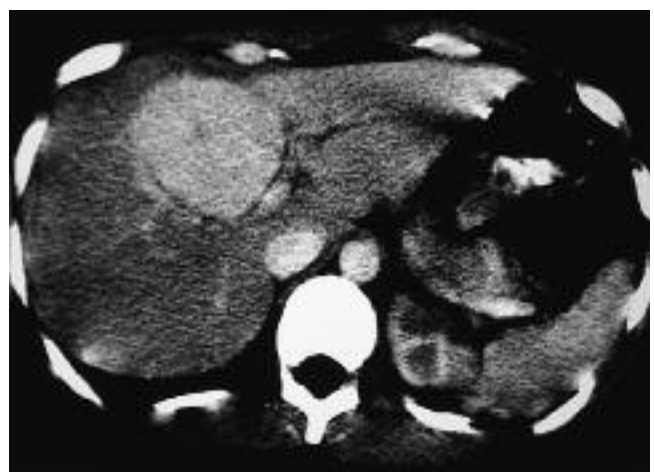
CT scan of a solid hepatic mass. The central 'scar' in this lesion suggests that it is focal nodular hyperplasia, which was confirmed on biopsy. Such a lesion could also represent an adenoma.
